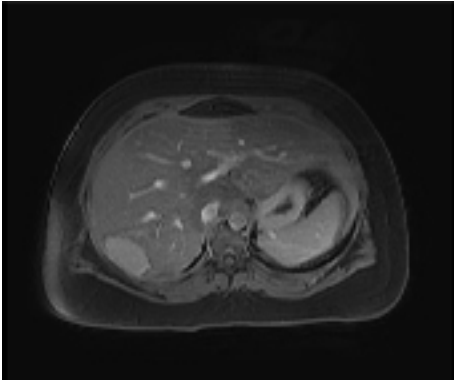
Magnetic resonance imaging of the segment 7 hepatic adenoma measuring 5.2 cm x 3.3 cm x 6.6 cm.
